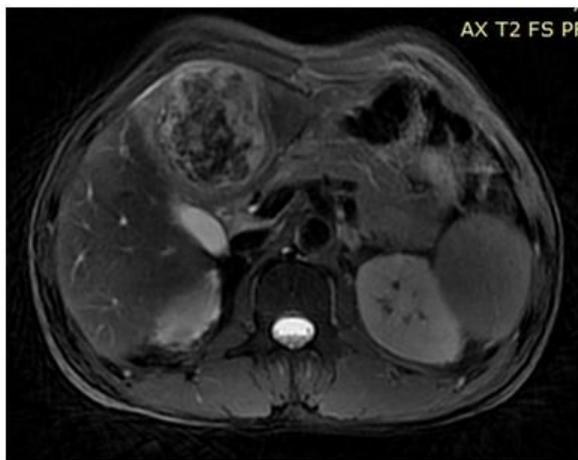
T2W axial MRI image showing heterogenous intensity lesion in left lobe of liver (case 1).
